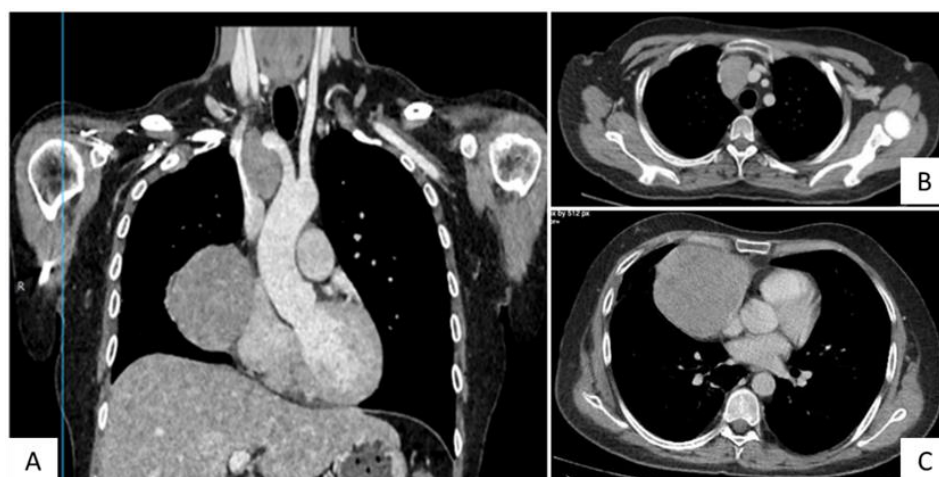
Coronal and transverse sections of a contrast-enhanced chest CT scan. A) Coronal section showing both anterior mediastinal masses, located on the right parasagittal plane; no connection between them is evident. B) Transverse section, first mass, measuring 47x47x37 mm. C) Transverse section, second mass, measuring 91x92x96 mm.
